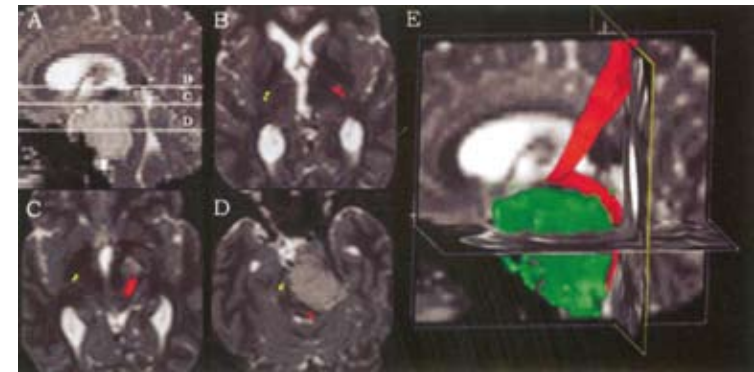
Deformation of the corticospinal tract in a patient with a meningioma. (A) Midsagittal T2-weighted image showing the extent of the tumor. (B-D) T2-weighted axial images with superimposed the left (yellow) and right (red) corticospinal tract. The section level is indicated on (A). (E) Triplanar view of the tumor rendered in green and the right CST in red.
